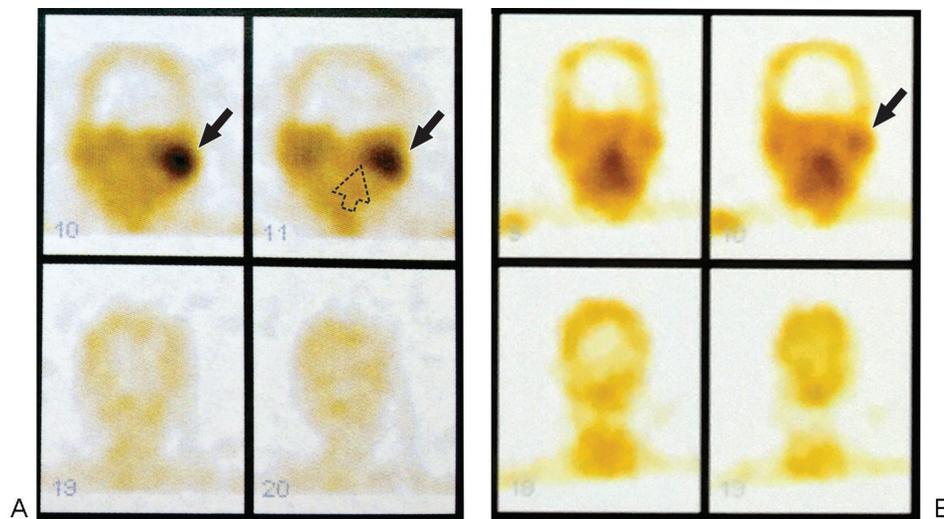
Single-photon emission computed tomography with gallium 67, coronal sections, before antibiotic therapy (A) and after intravenous antibiotic therapy (B), case number four. (A), Accumulation of the radiopharmaceutical at the left mastoid region (black arrow) and at the left sphenoid and maxillary sinuses topography (dotted arrow). (B), Significant reduction of radiopharmaceutical accumulation compared to the previous examination (A), and persistence of minimal accumulation at the left mastoid bone (black arrow).
